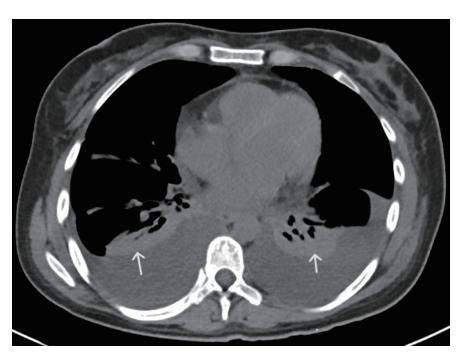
CT of chest with contrast (axial view) showing bilateral pleural effusions and adjacent atelectasis (white arrows). CT: computed tomography.
